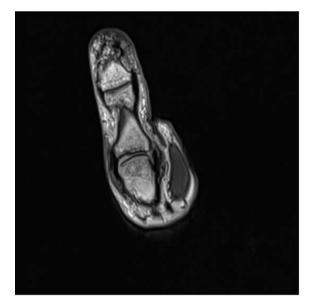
Coronal, T2 weighted MRI of the thumb demonstrating rupture of the ulnar collateral ligament off of the proximal phalanx.
